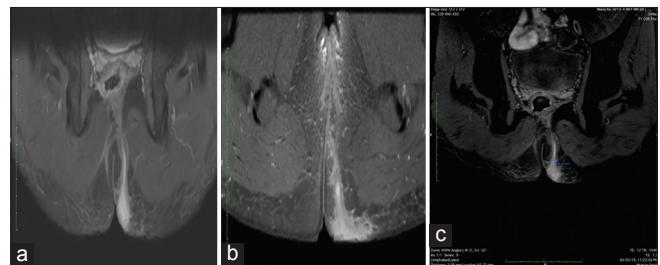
Series of images (a-c) showing case of active intersphincteric fistula with ramifications (magnetic resonance imaging Grade II). Fistula tract is showing enhancement in T1 post-contrast image (c). (a) T2 coronal fat-sat. (b) Axial T2 fat-sat. (c) Coronal T1 post-contrast fat-sat
